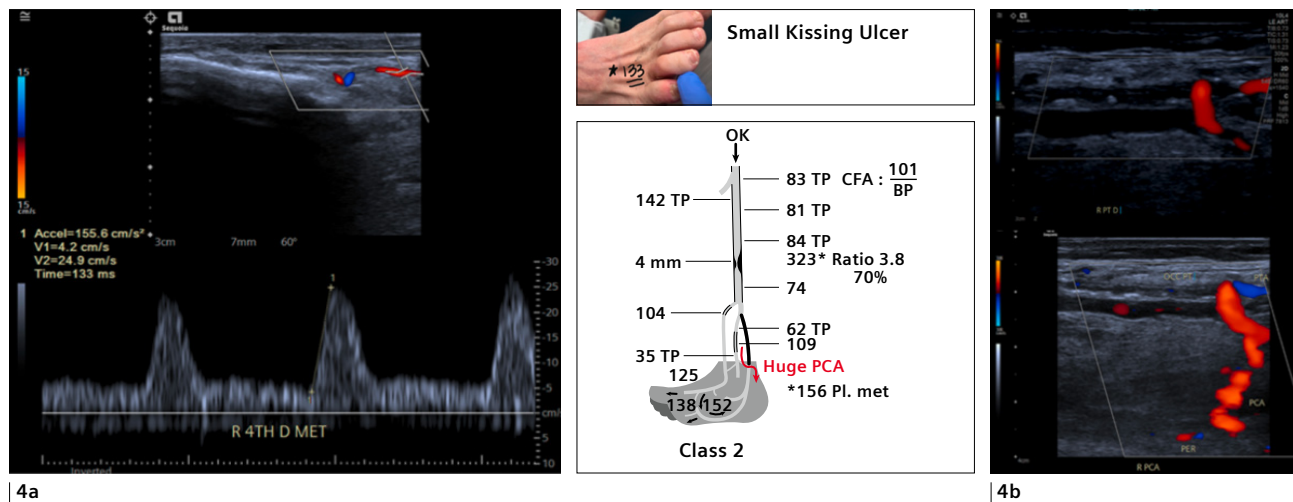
Initial ultrasound demonstrating Class 2 PAT at the wound bed. Pedal acceleration time (PAT) to the wound bed demonstrates class 2 perfusion (4a). Posterior communicating artery (PCA) well visualized demonstrating indirect perfusion to the plantar arch circulation (4b).
